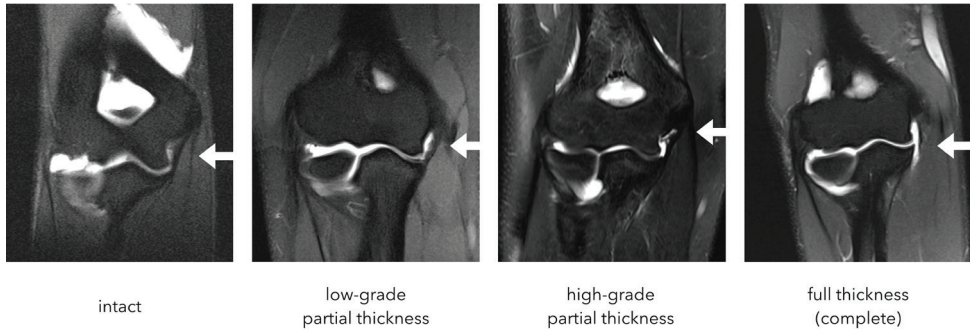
MRI-based classification of ulnar collateral ligament injuries (white arrows) into 4 categories: intact; edema or low-grade partial thickness tears; high-grade partial-thickness tears; and complete full-thickness tears.
